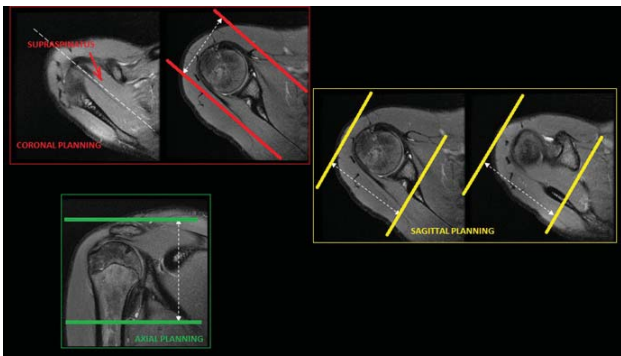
MRI Shoulder planning. Note the coronal images are planned parallel to long axis of supraspinatus muscle belly and sagittal images are planned perpendicular to long axis of supraspinatus
